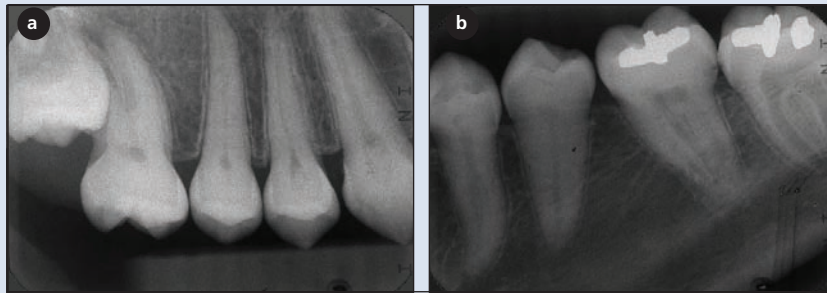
Periapical radiographs at age 18 years 6 months (patient no. 3): (a) upper right and (b) lower left quadrants. Tooth 36 was extracted 5 years 9 months earlier; tooth 16 was extracted 2 years 2 months earlier. Healing is apparently complete at both extraction sites. Generalized pulpal calcification is progressing.
